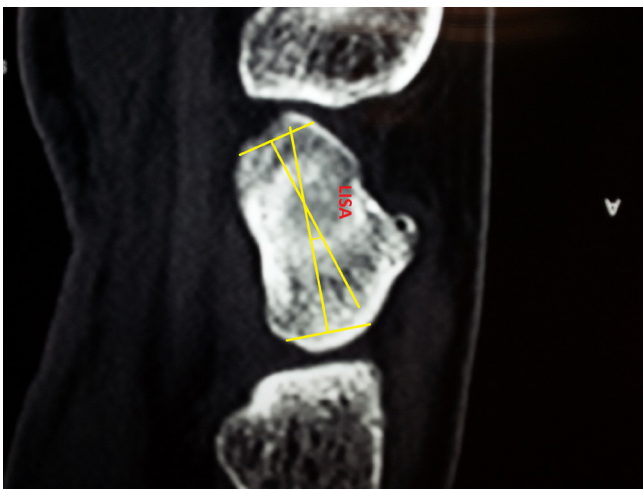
The lateral intrascaphoid angle (LISA) was measured by the intersection of the two perpendicular lines drawn from the distal and proximal scaphoid articular surfaces on sagittal CT cuts.
